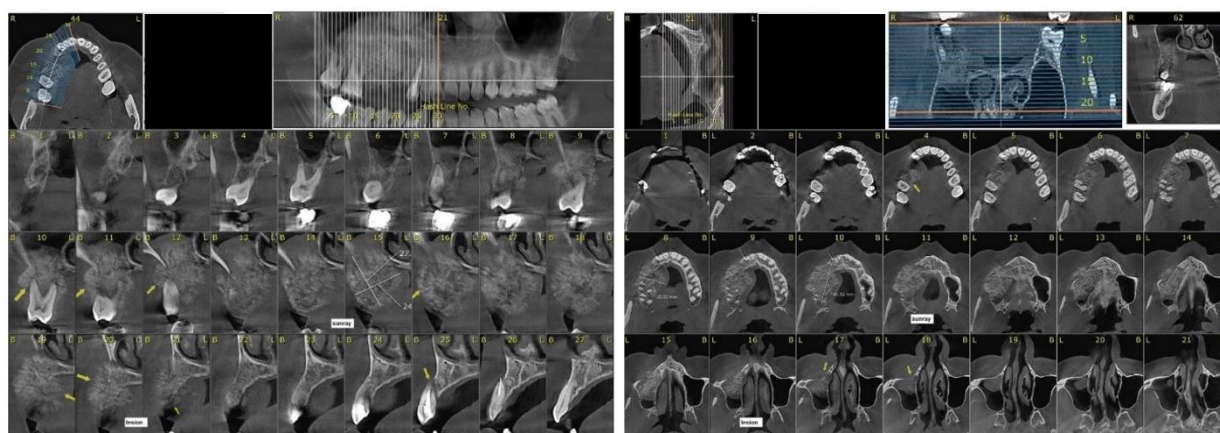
CBCT findings of the patient.
